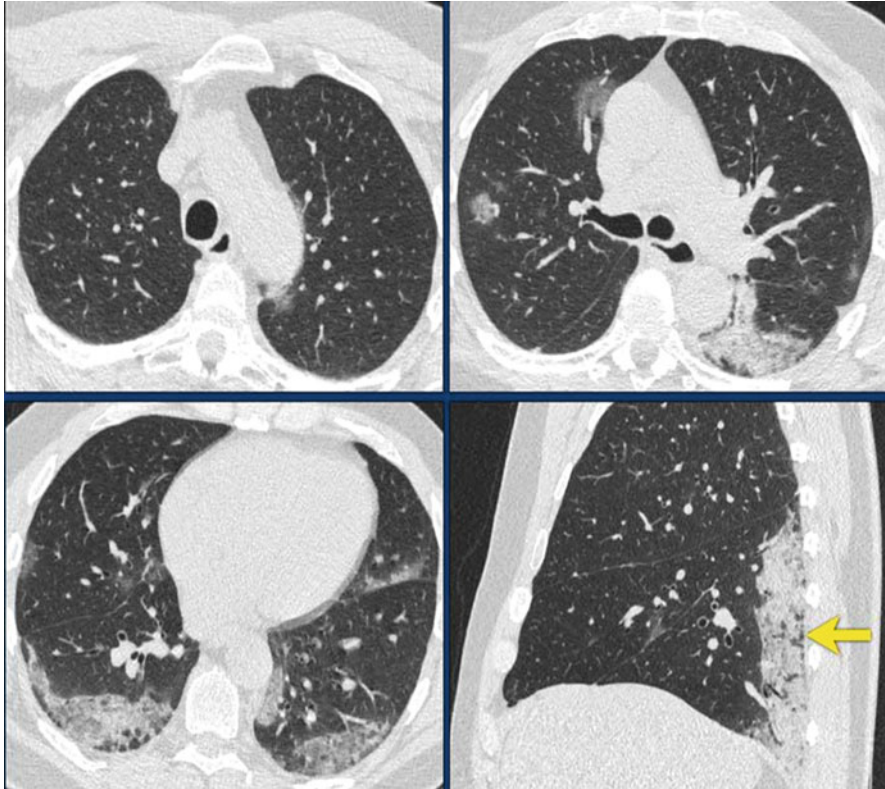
Visualization of a 59-year-old male with fever for 1 week with non-productive cough. Due to the high clinical suspicion CT, some areas of ground glass opacities (GGO) and massive consolidation in the posterior parts of the lower lobes (yellow arrow on sagittal reconstruction) were observed and the results of RT-PCR were negative. A sputum test was performed after 2 days which resulted as positive (The Radiology Assistant [n.d.](#))
